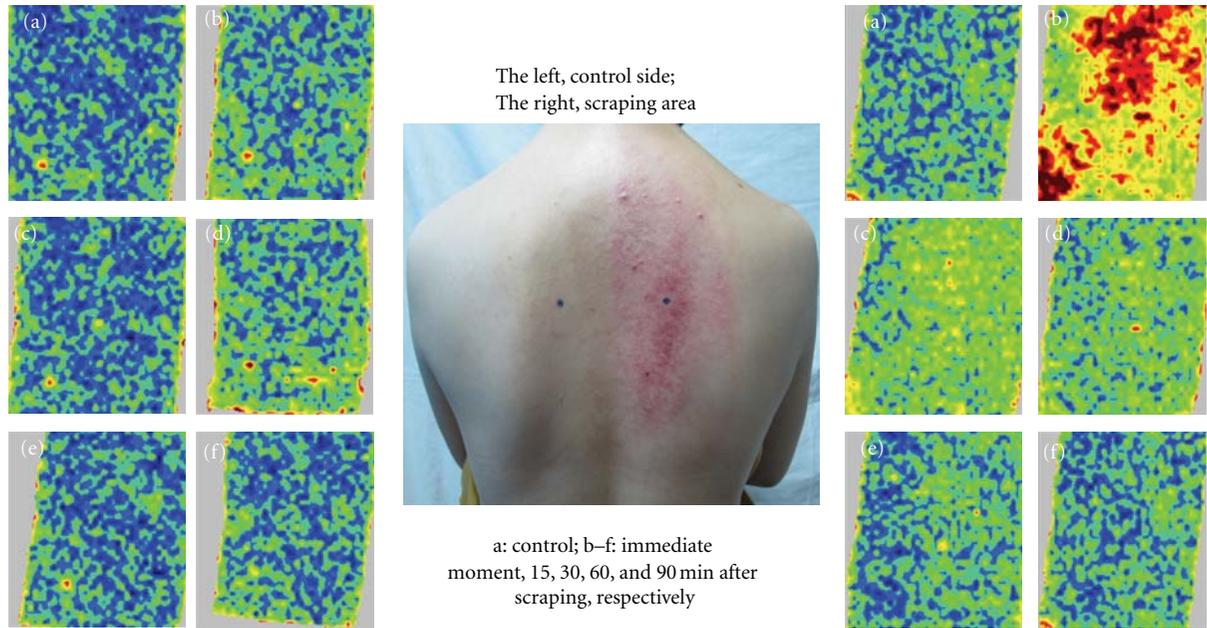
Visual image (middle) taken at 5 min after scraping showed that the skin of the scraping area turned apparently red. Laser Doppler images (left, non-scraping side; right, scraping side) showed the blood perfusion volume. Images (a)–(f) were taken at 5 min before scraping, 0 min, 15 min, 30 min, 60 min and 90 min after scraping stimulation, respectively.
